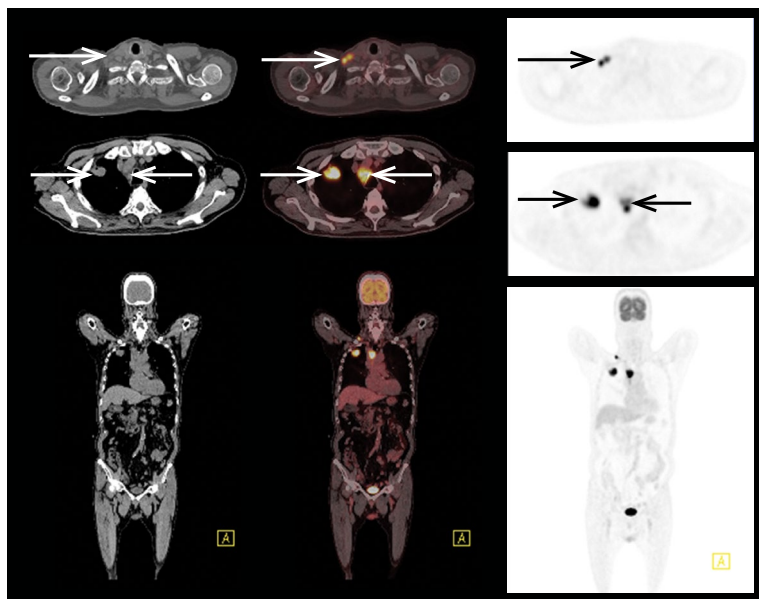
CT, PET and fused PET/CT images show ^{18}F -FDG-avid right upper lobar mass (arrows) and enlarged hypermetabolic right supraclavicular and mediastinal (right paratracheal) lymph nodal metastases (arrows).
